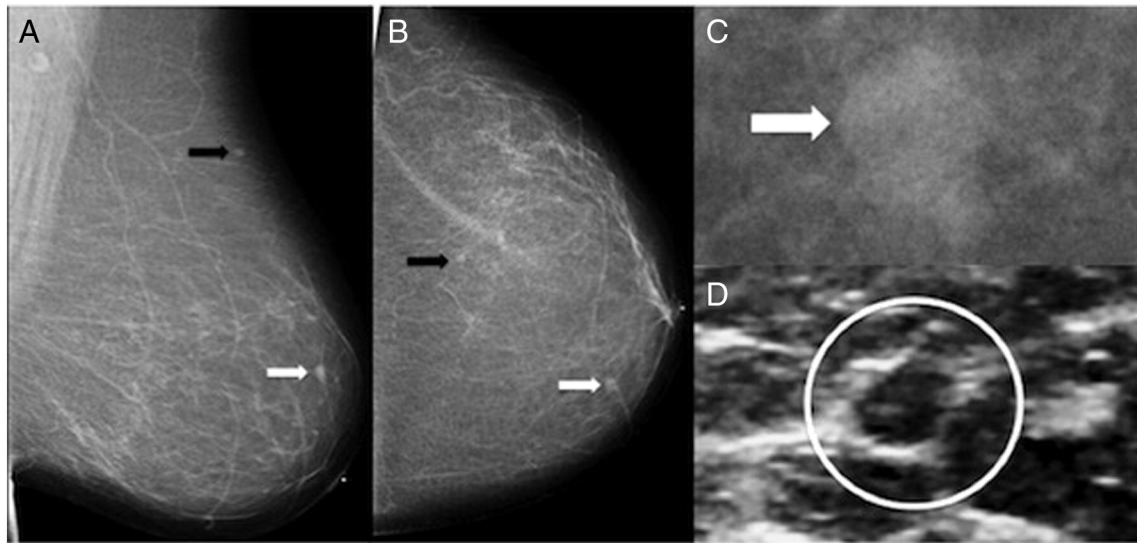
Case 1: mammogram and ultrasound of the left breast. Two new small masses were seen in the left breast, 0.5 cm at 11:00 anterior depth (white arrow) and 0.4 cm at 1:00 posterior depth (black arrow) on the mediolateral-oblique (A) and craniocaudal (B) views. Craniocaudal spot compression view (C) of the 0.5-cm mass shows the mass to have microlobulated and indistinct margins. An oval hypoechoic mass (white circle) with microlobulated margins was seen on targeted ultrasound for the 0.5-cm mass (D). No sonographic correlate was seen for the smaller 0.4-cm mass.
